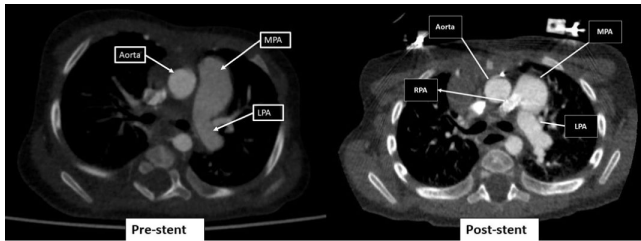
Pre-stent: Computed tomography angiogram demonstrating right pulmonary artery disconnection Post-stent: Computed tomography angiogram demonstrating right pulmonary artery connection and patent stent lumen.
